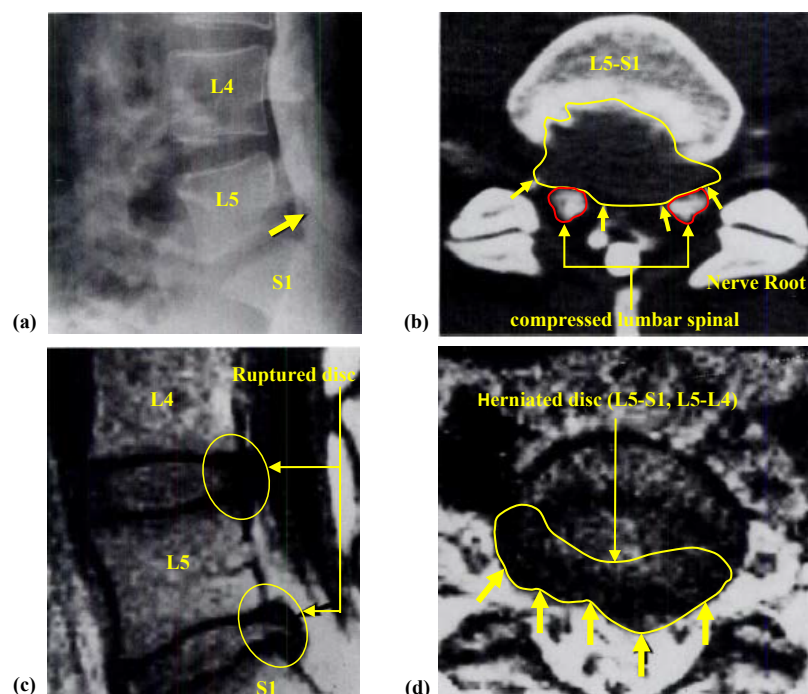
Standard profile of the lumbar sacral spine radiograph of a boy of 16 years showing: (a) disc pinching (L5-S1, L5-L4), (b) TDM lumbosacral of spine axial section showing a herniated disc median (L5-S1) posterolateral left, (c) lumbosacral MRI showing a posterior disc herniation (L5-S1), progression disc level (L5-L4), (D) MRI axial section showing a posterolateral disc left hernia (S1-L5) [47].
